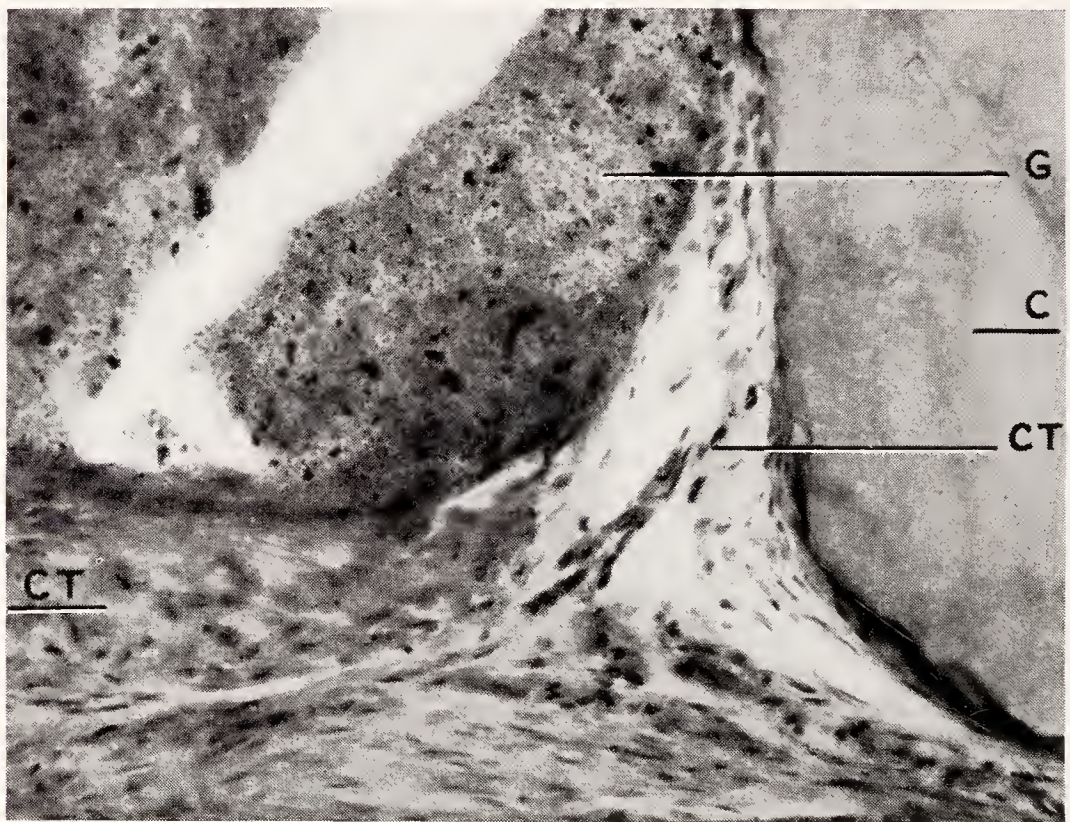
High magnification of Figure 209. *G*, guttapercha; *C*, cementum; *CT*, fibrous connective tissue of periodontal membrane lying in direct contact with guttapercha and wall of root canal. Notice the absence of any inflammatory reaction in the periapical connective tissue. (Coolidge, Jour. Am. Dent. Assn.)
